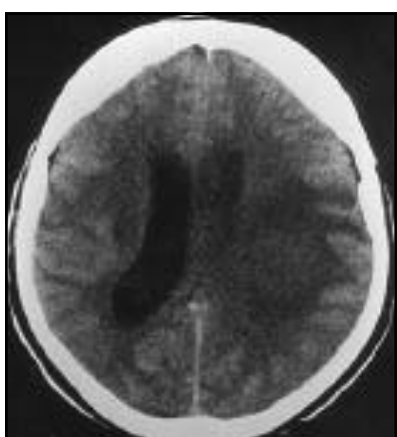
Brain CT without contrast showing edema of the left hemisphere with isodense material in the left lateral ventricle that proved to be pus.
